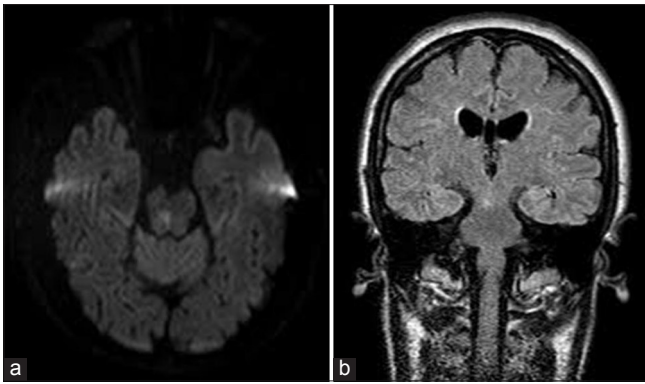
Magnetic resonance images performed 1 day after the stroke event. We can see a right medial mesencephalic lesion that exhibits restricted diffusion in diffusion-weighted imaging (a), hypointense signal in T1 sequence and hyperintense signal in coronal T2-fluid attenuated inversion recovery image (b). The appearance of the lesion described in the images is highly suggestive of an acute mesencephalic infarct
